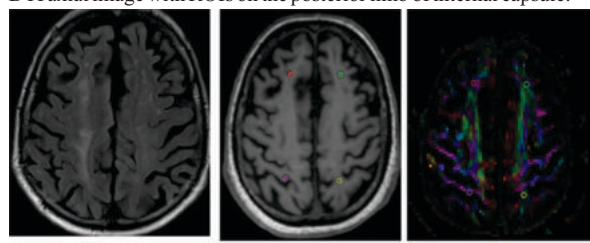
a- i. MRI Diffusion tensor post-processed colour coded images with ROI drawn on different regions of white matter (WM) to measure FA values of white matter at different predefined regions. This participant has normal routine non-contrast MRI scan of brain.
